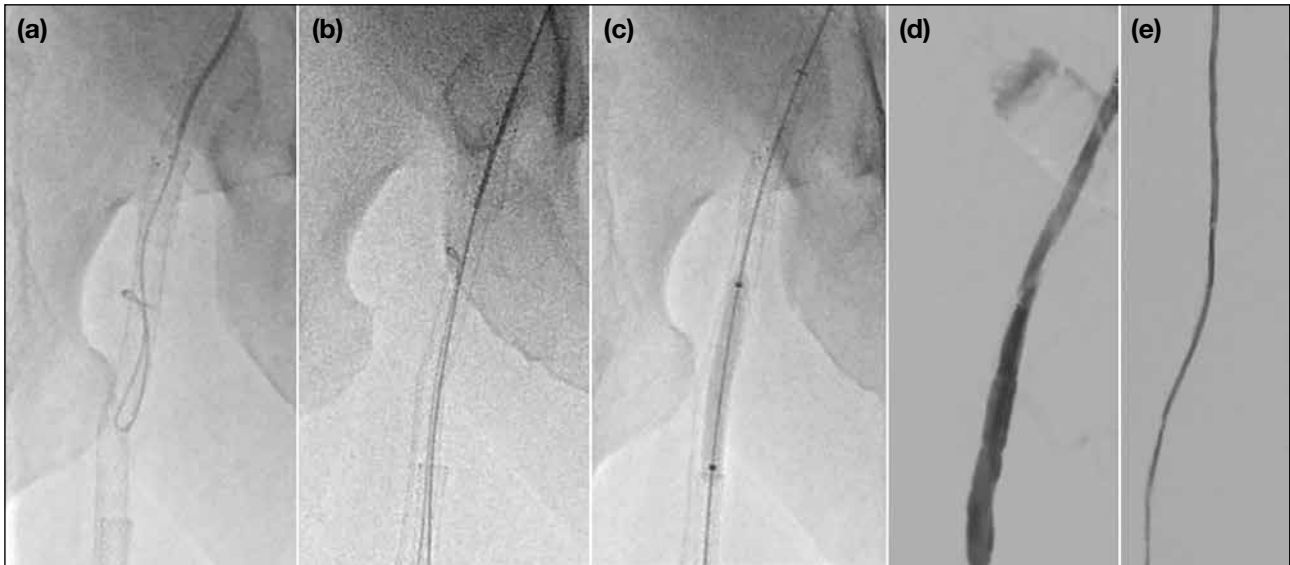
Digital subtraction angiography images of angioplasty and double-barrel stenting performed in November 2023. (a) Crossover wire from left femoral access, with the tip positioned within the right common femoral artery to the proximal superficial femoral artery (CFA-pSFA) stent, encountering resistance due to occlusion. The occlusion was eventually navigated; however, in view of failure to re-enter the mid superficial femoral artery (mid-SFA) stent lumen, a retrograde approach was employed. (b) A 0.018-inch retrograde wire via right posterior tibial artery access was advanced intraluminally through the occluded distal superficial femoral artery popliteal artery stent, with subsequent entry into the subintimal space outside the Zilver SFA stent and re-entry into the intraluminal occluded CFA stent. The long sheath from the left groin access was cannulated by the retrograde wire and subsequently externalised, establishing a through-and-through floss wire. Position was confirmed by intravascular ultrasound (Figure 6). (c) After establishment of the floss wire, angioplasty of the intraluminal-subintimal-intraluminal wire tract was performed. (d, e) Angioplasty of the posterior tibial artery and tibioperoneal trunk was performed, followed by mid-SFA stenting with double-barrel exclusion of the Zilver stent. Completion angiography showed significant restoration of flow between the newly deployed mid-SFA stent and adjacent stents.
